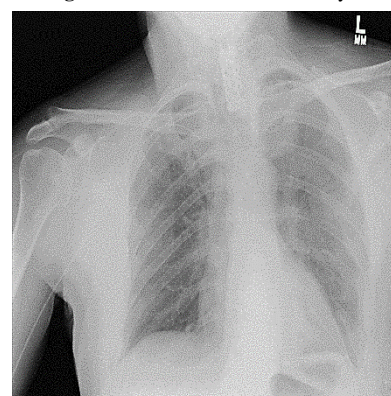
Pneumonia Chest X-ray
